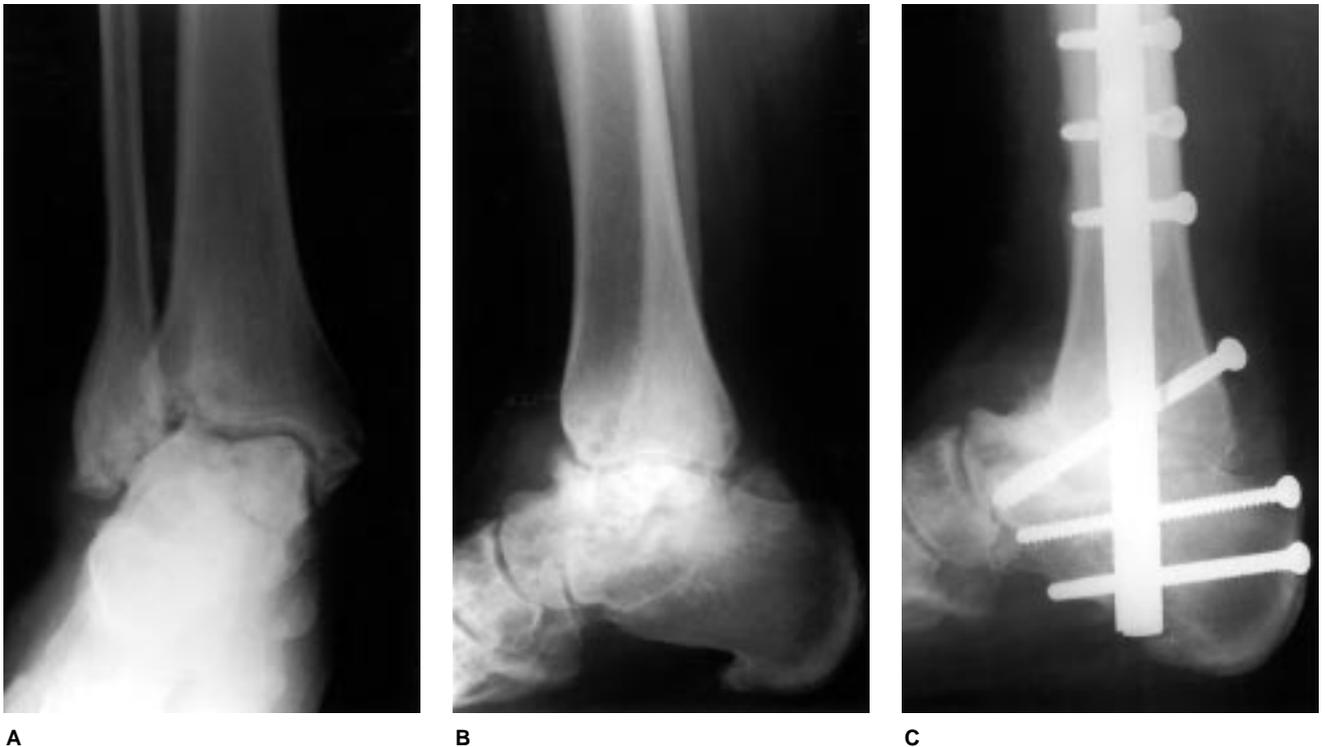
AP (A) and lateral (B) plain radiographs demonstrate osteonecrosis of the entire talar body. C, Lateral postoperative radiograph shows tibio-calcaneal arthrodesis with intramedullary nail fixation. The necrotic talar body was removed.
